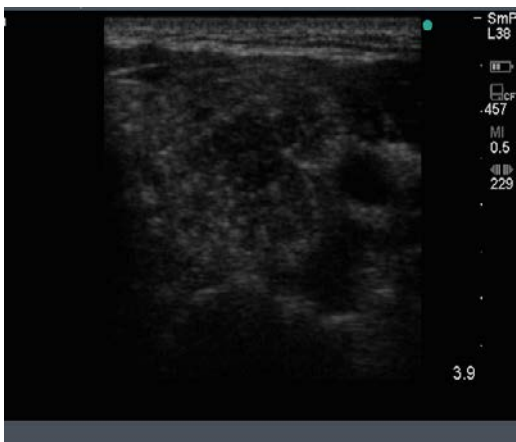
Thyroid ultrasound from a patient with confirmed papillary thyroid cancer. The nodule is large (3 cm) and hypoechoic with an indistinct irregular edge and central micro calcifications. The calcifications are softer (less white) that seen above in some benign nodules and larger, around 2-3 mm (arrow). There is no halo. Not seen here, the blood supply was increased in the lesion and there was a feeding vessel on one side of the lesion.
